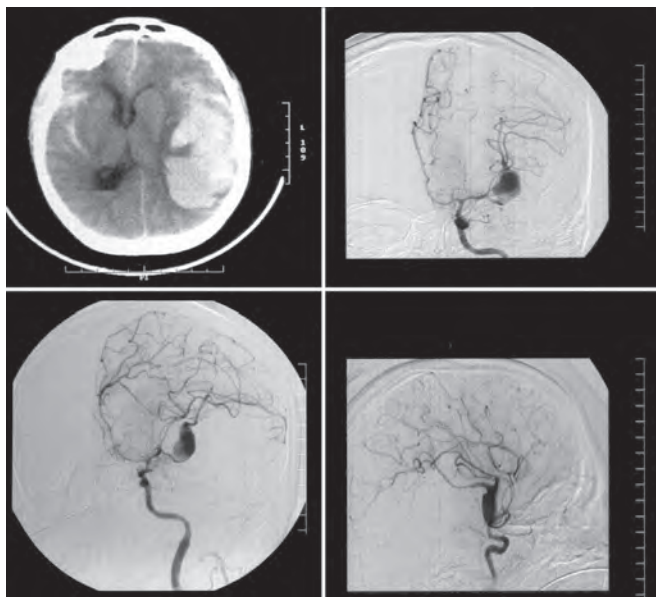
CT and DSA—large Lt. temporoparietal ICH and partially thrombosed large MCA bifurcation aneurysm
